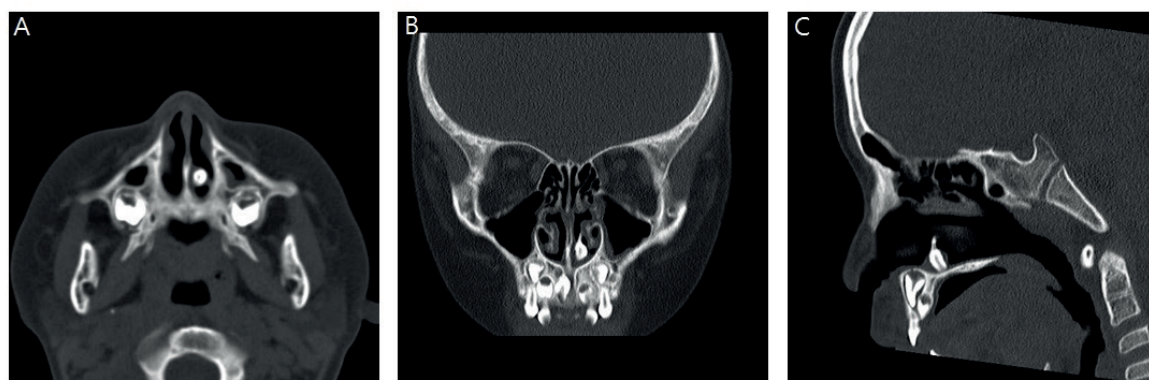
Computed tomography (CT) of paranasal sinuses: Tooth observed in left nasal cavity floor. A. axial view, B. coronal view, C. sagittal view.
